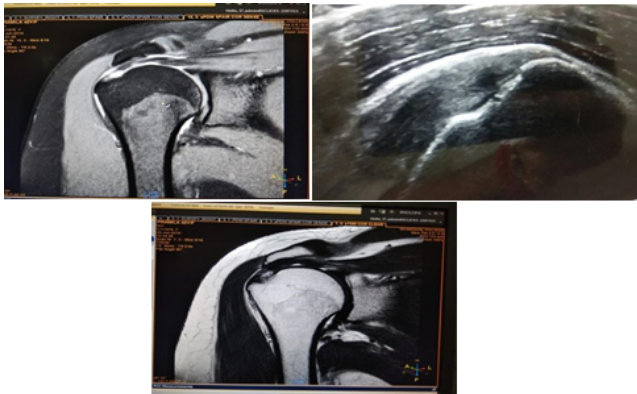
(a) USG images showing partial tear of SST. (b) MRI, T2W coronal images showing partial tear of Infraspinatus. (c) MRI, PDW coronal images showing partial tear of SST and fluid in sub deltoid bursa sub acromial bursa
